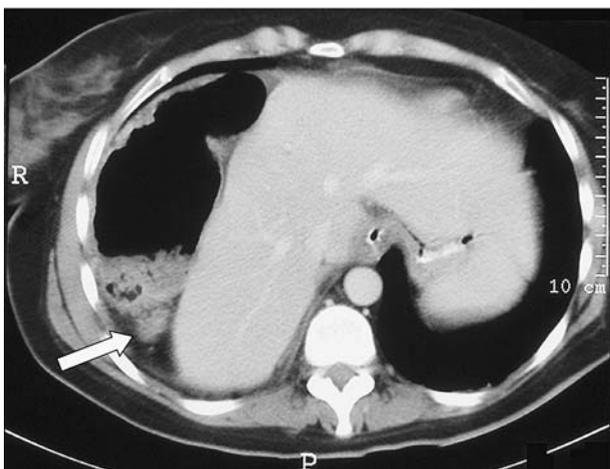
CT scan of thorax showing right-sided diaphragmatic herniation with a proximal dilated bowel loop and a distal collapsed loop (arrow)
